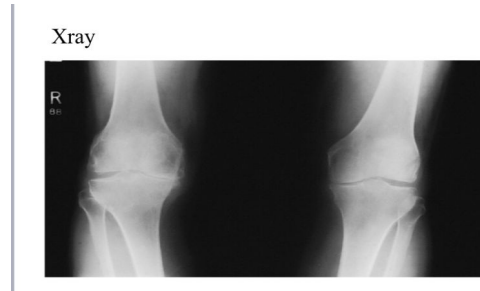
Radiograph of tibiofemoral OA, showing joint space narrowing, sclerosis, and osteophyte
